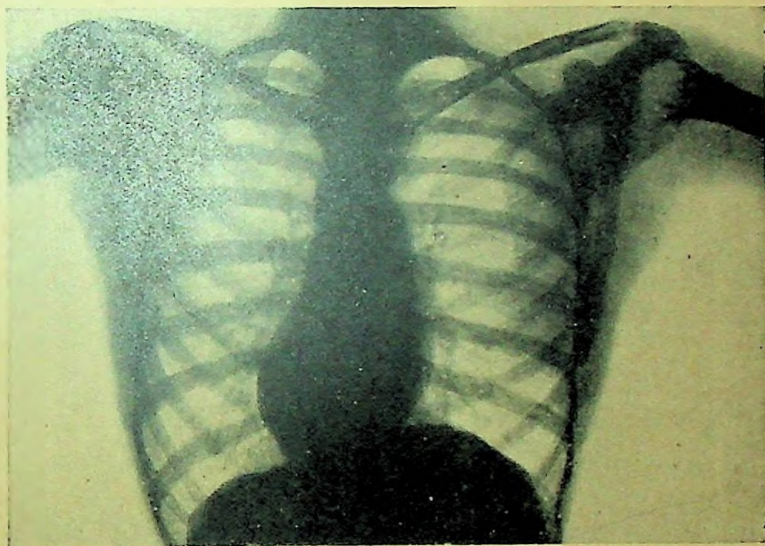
X-RAY PHOTO. CHEST WITH OUTLINE OF THE HEART.
